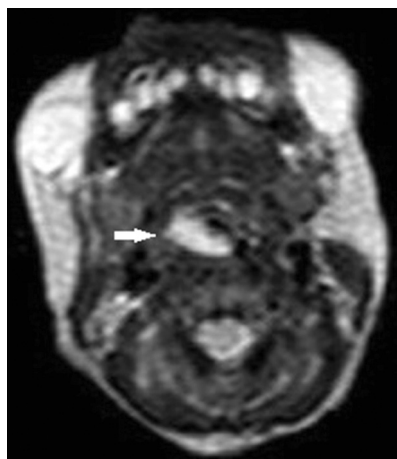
A mass in the larynx partially obstructs the airway on axial MRI (white arrow)
